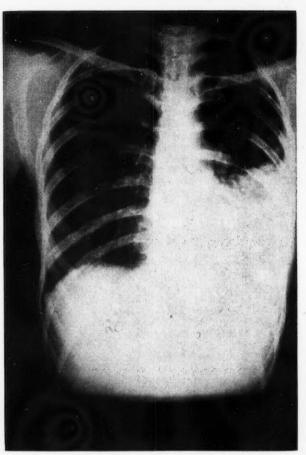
Chest radiograph, September 20, 1954.
